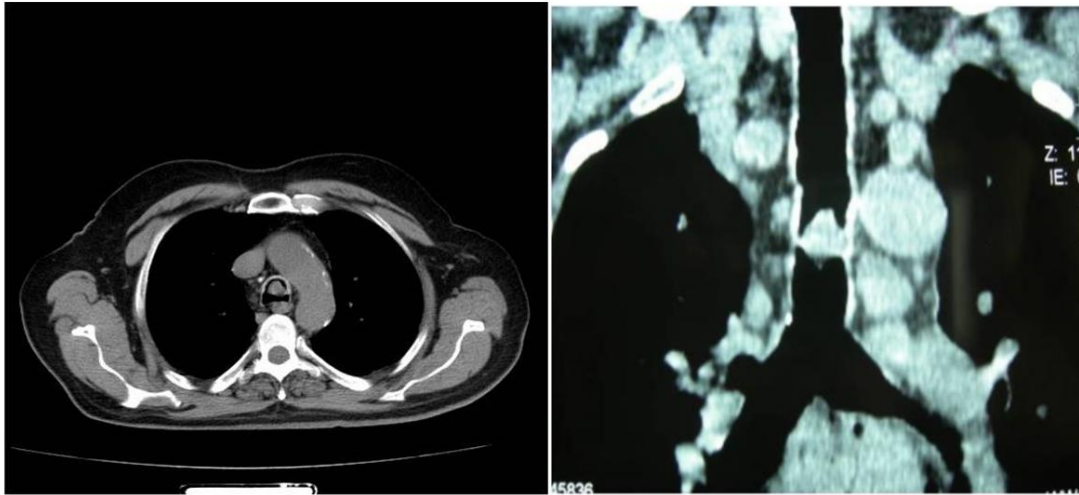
and Figure 2B: thorax CT, in addition to the lesion
